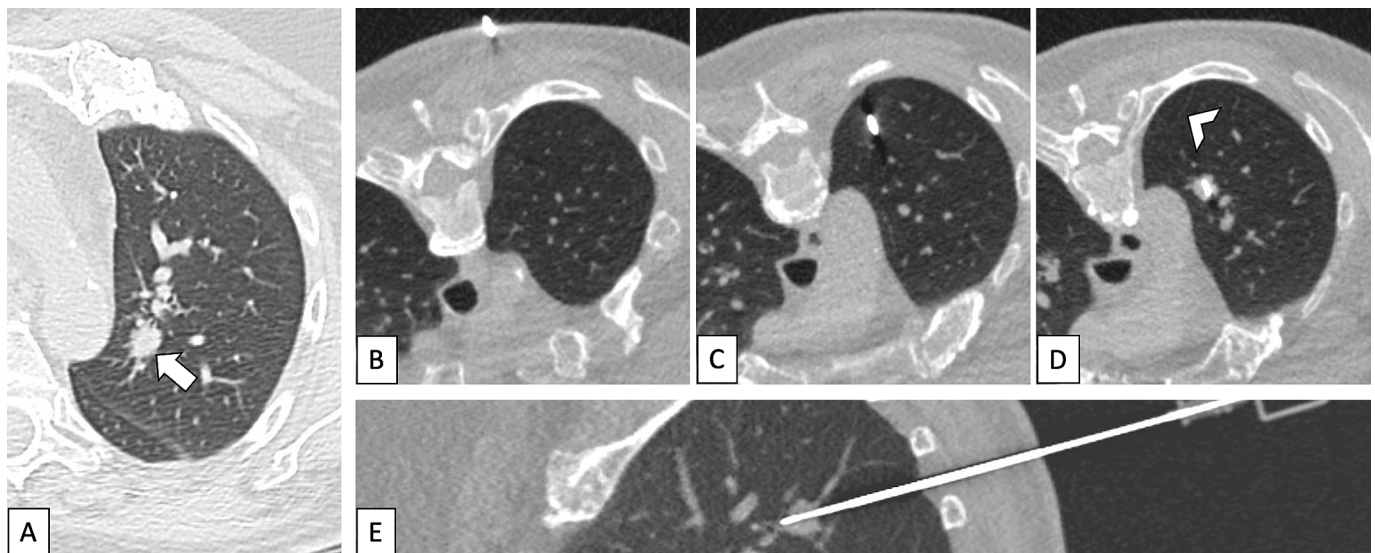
A-E. CT-guided transthoracic core needle biopsy of a central solid nodule located in the left upper lobe (arrow). B-D. Axial images from the up (B) to the bottom (D) depict an oblique approach, which was adopted to avoid interception of the nearby fissure (arrowhead) and vessels. E. Volumetric acquisition was performed to assess the oblique needle course and proper groove positioning within the lesion. The final diagnosis was lung adenocarcinoma.
